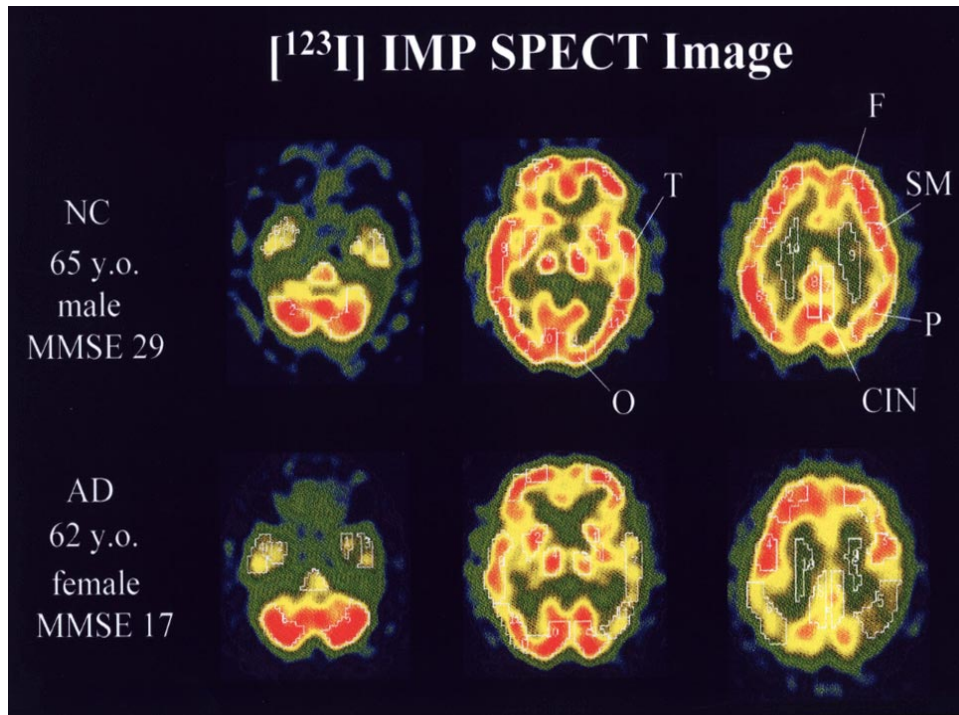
Typical [^{123}I]IMP SPECT image (“early” images) in a normal subject (*top*) and a patient with AD (*bottom*). There is a relatively large reduction in the temporoparietal cortices and posterior cingulate cortex in patients with AD. The abbreviations of region names are as follows: F (superior frontal cortex), SM (sensorimotor cortex), T (temporal cortex), P (parietal cortex), OC (occipital cortex), CIN (posterior cingulate cortex).
